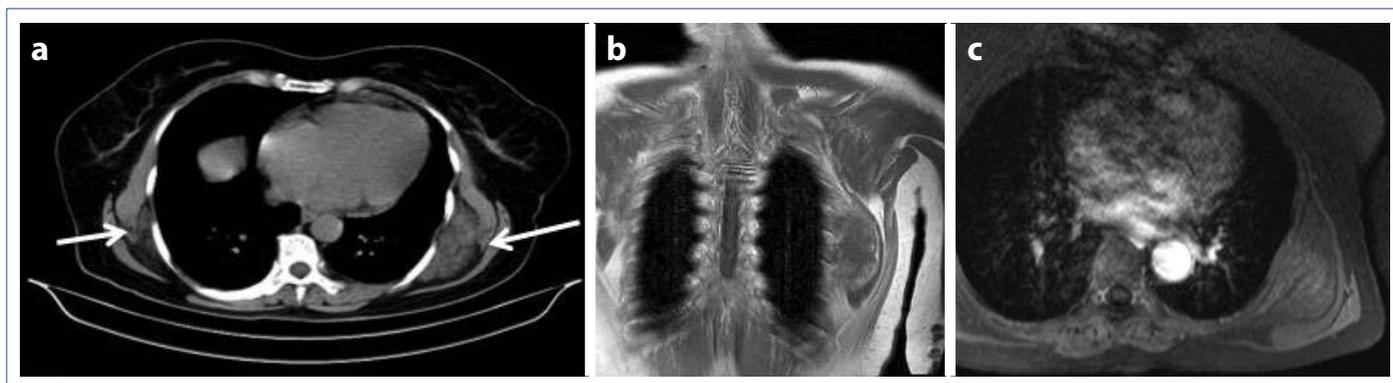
Thorax CT (a) and MRI (b, c) sections of left sided soft tissue mass under latissimus dorsi.
